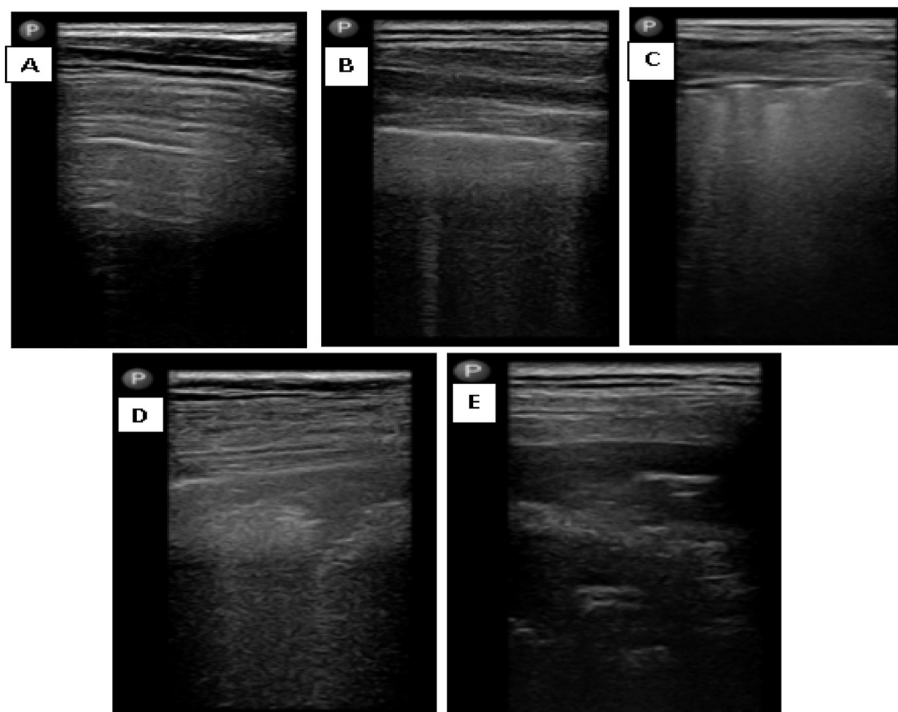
Ultrasound patterns in COVID-19. (A) Score 0: horizontal A-lines; (B) Score 1: B-lines <50% of surface; (C) Score 2: coalescent B-lines >50% of surface; (D) Score 3: subpleural consolidation “shred sign”; (E) Score 3: alveolar consolidation with bronchogram.
